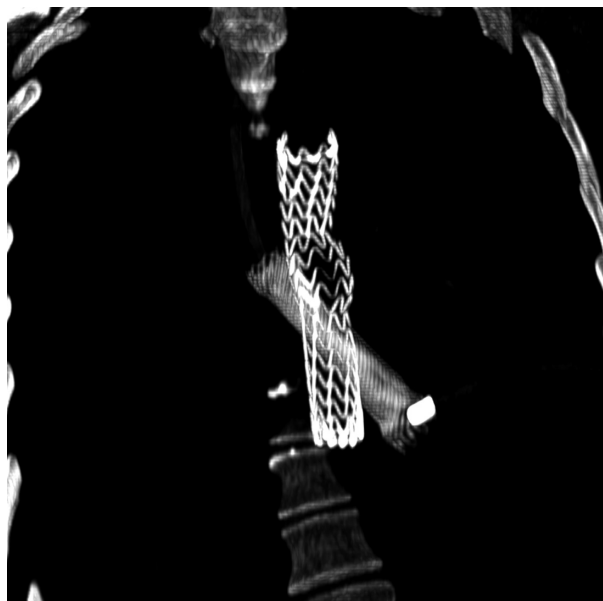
Postintervention coronal CT showing both endovascular and esophageal stents in situ.
